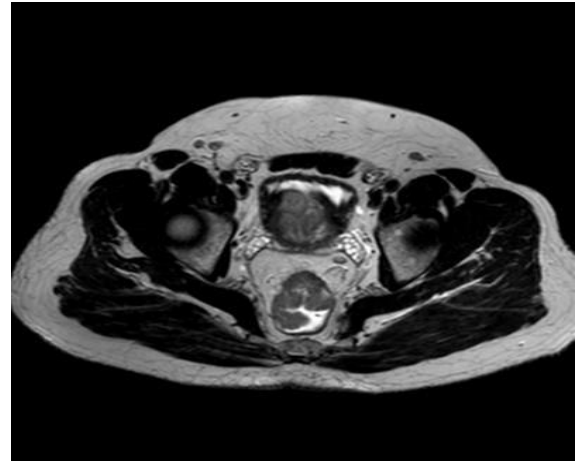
Initial MRI pelvis showing a rectal tumor with enlarged mesorectal lymph nodes.
